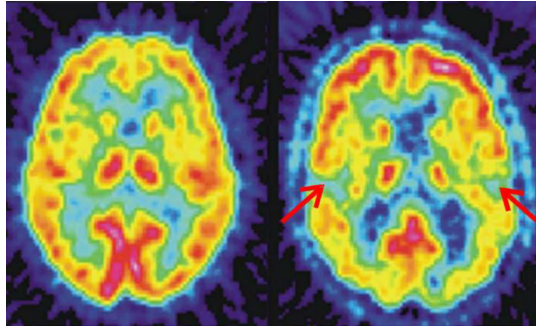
Quantitative brain PET image with $[^{18}\text{F}]$ -fluoro-deoxyglucose (FDG). Left: for healthy volunteer, right: for Alzheimer's patient. The red arrows indicate the areas of loss of the neurons in the occipitotemporal cortex (Herzog et al. 2018).
